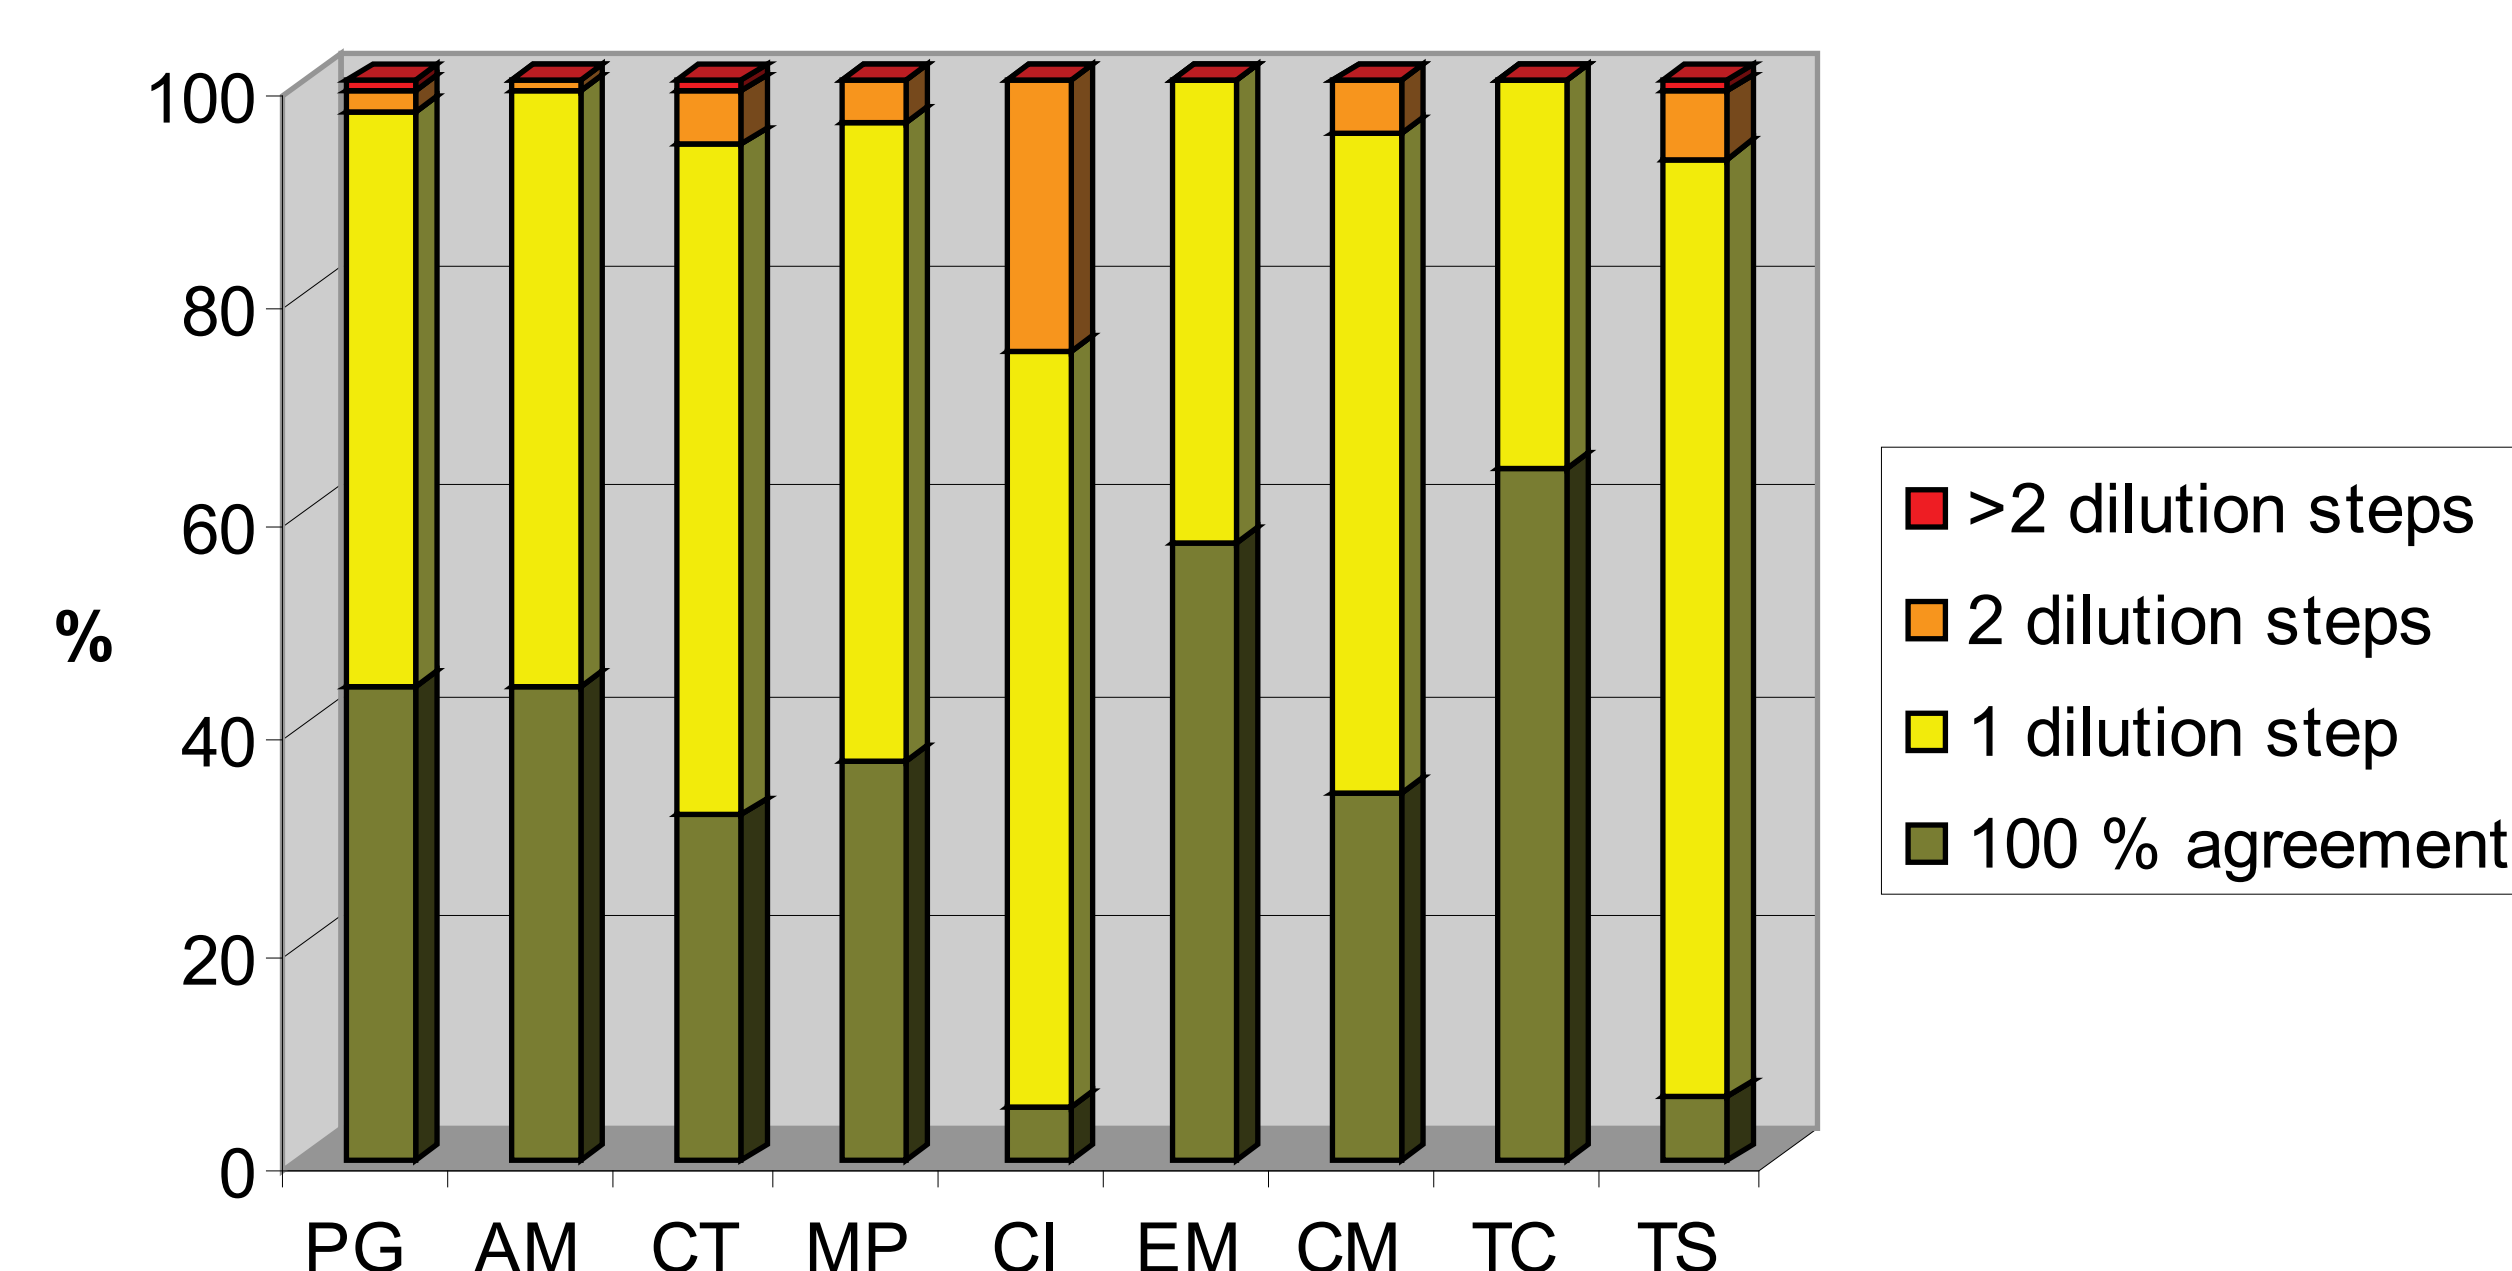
The overall agreement in percentage between MIC-values for the MIC test strip compared to the Etest. PG: penicillin G; AM: ampicillin; CT: cefotaxime; MP: meropenem; CI: ciprofloxacin; EM: erythromycin; CM: clindamycin; TC: tetracycline; and TS: trimethoprim-sulphamethoxazole.
